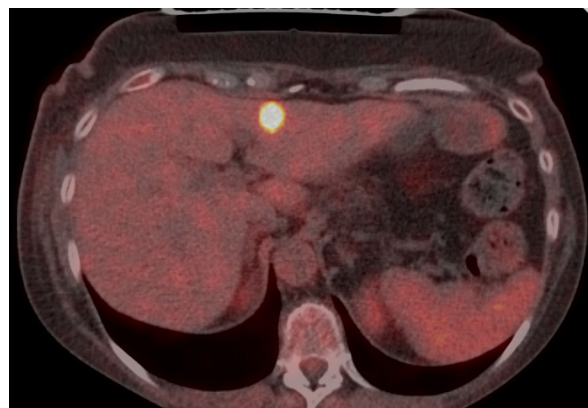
PET-CT imaging at the start of therapy with TDxd, showing one of the liver metastases.
